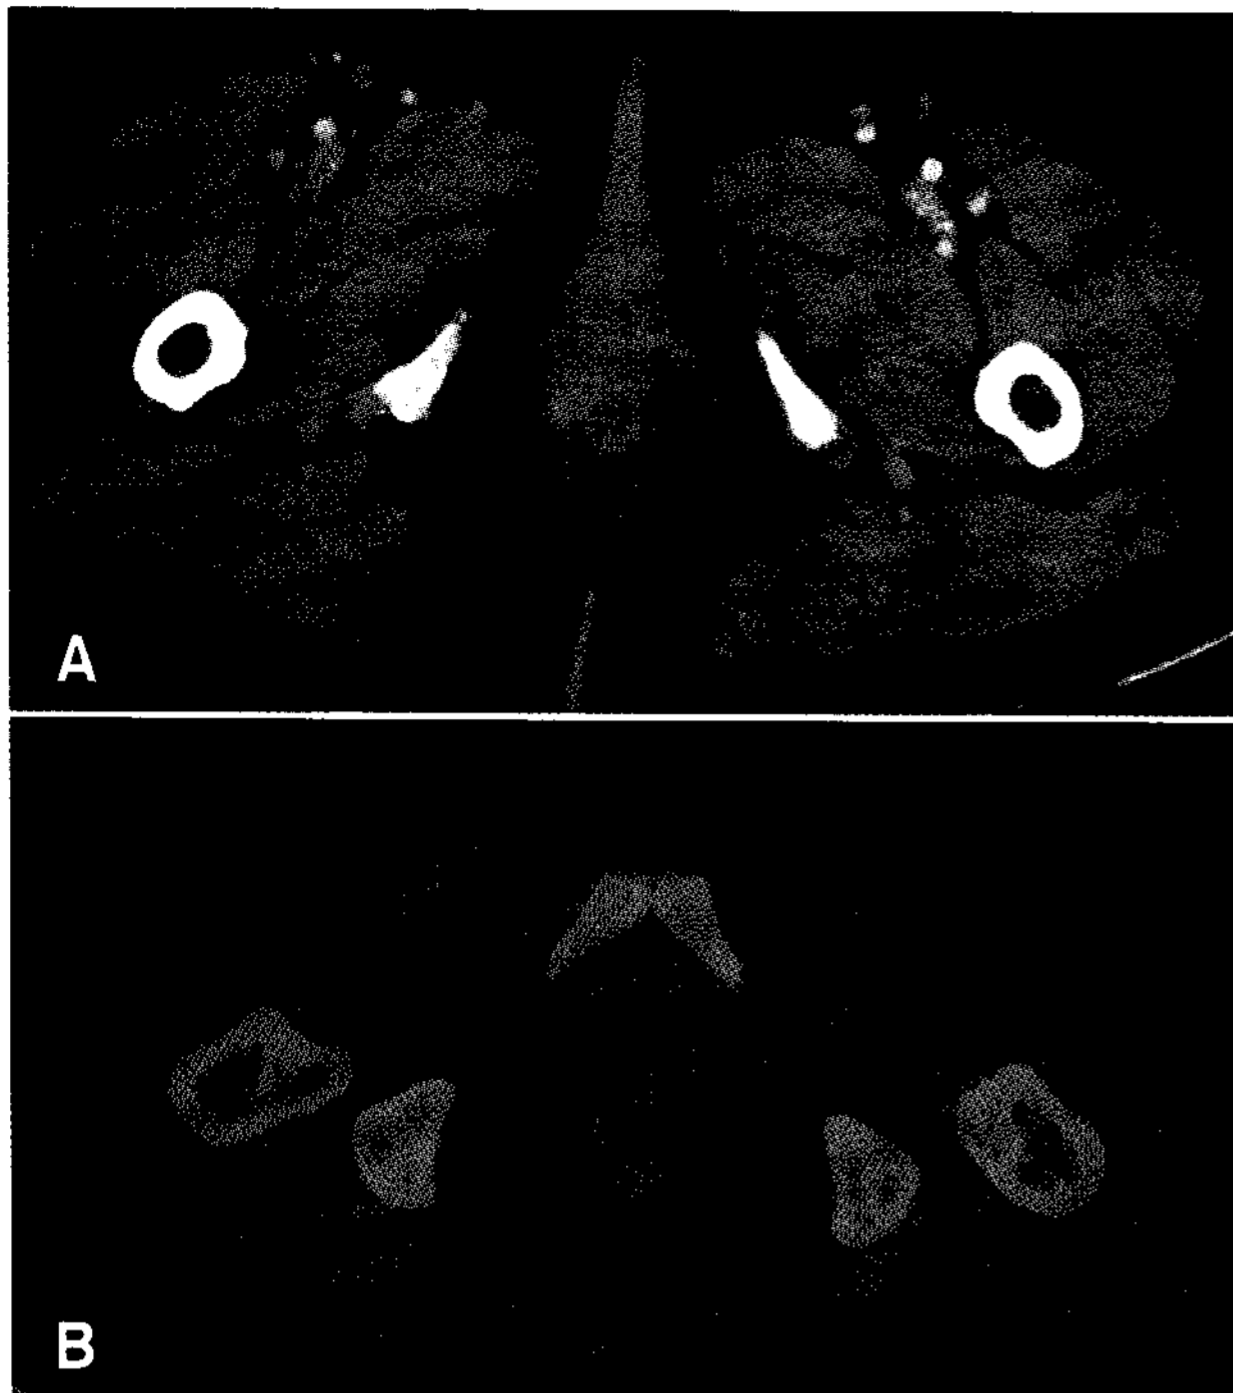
This 56 year old patient received second look operation and chemotherapy for metastatic serous adenocarcinoma. Follow-up CA 125 level was normal 1.83 IU/mL, but enhanced CT image (A, arrow) shows focally enhancing lesion in right perineum, and in the fusion image of PET/CT image (B) focal FDG uptake is also perceptible in the same area (arrow). Biopsy confirmed the lesion to be benign perivascular mononuclear cell infiltration.
